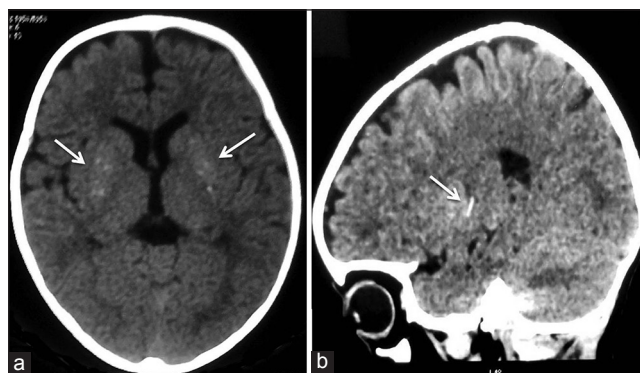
Neuroimaging of the child (a) Axial CT head image shows bilateral punctate lentiform nuclei calcifications (b) The sagittal image shows mineralization of the lenticulostriate artery (arrow). CT = Computed tomography
